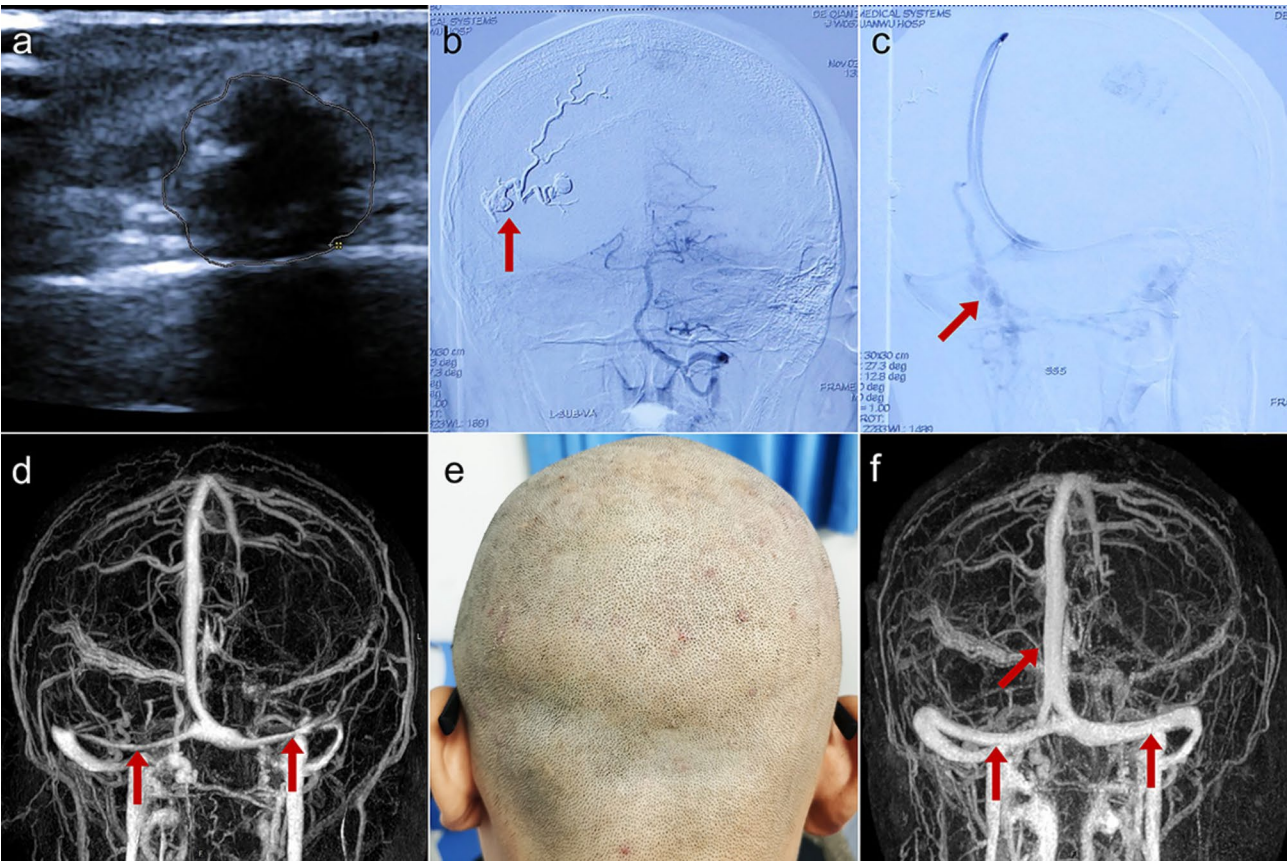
Follow-ups: Postoperative ultrasonography showed the disappearance of abnormal blood flow (A). Re-exploration of DSA (B, C) 1-month post-operative revealed successful obliteration of the AVF (red arrow), and a draining vein between the superior sagittal sinus and occipital vein (red arrow), CE-MRV (D) showed that bilateral transverse sinus remained slender (red arrows). Eight-month follow-up showed no pulsatile lump in the occipital scalp (E), and CE-MRV (F) showed dilated venous sinuses (red arrows) and disappearance of the abnormal vascular mass in the right occipital region
